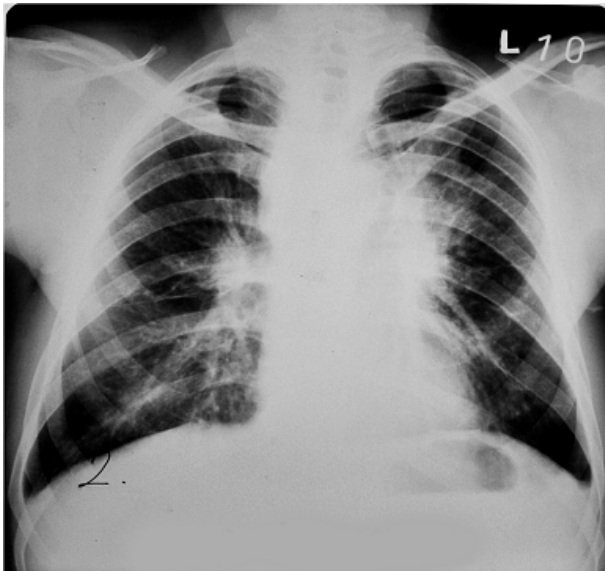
Chest radiography: hilar adenopathy and both-sided interstitial changes in the lung parenchyma.
